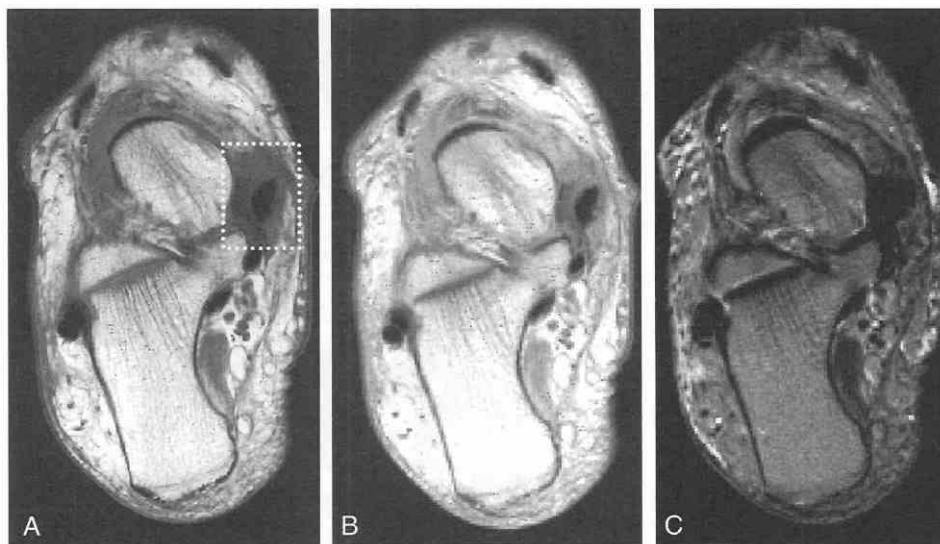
The patient (same as in Fig. 47-38) is a 57-year-old woman with chronic pain in the distribution of the posterior tibial tendon. *A*, Axial T1-weighted image shows abnormal dark signal rather than fat surrounding the posterior tibial tendon (*dotted rectangle*). *B*, Axial proton-density-weighted image at the same level as *A*. *C*, Axial T2-weighted image at the same level as *A* and *B* reveals no fluid surrounding the posterior tibial tendon, indicating that this is chronic scarring (stenosing tenosynovitis).
